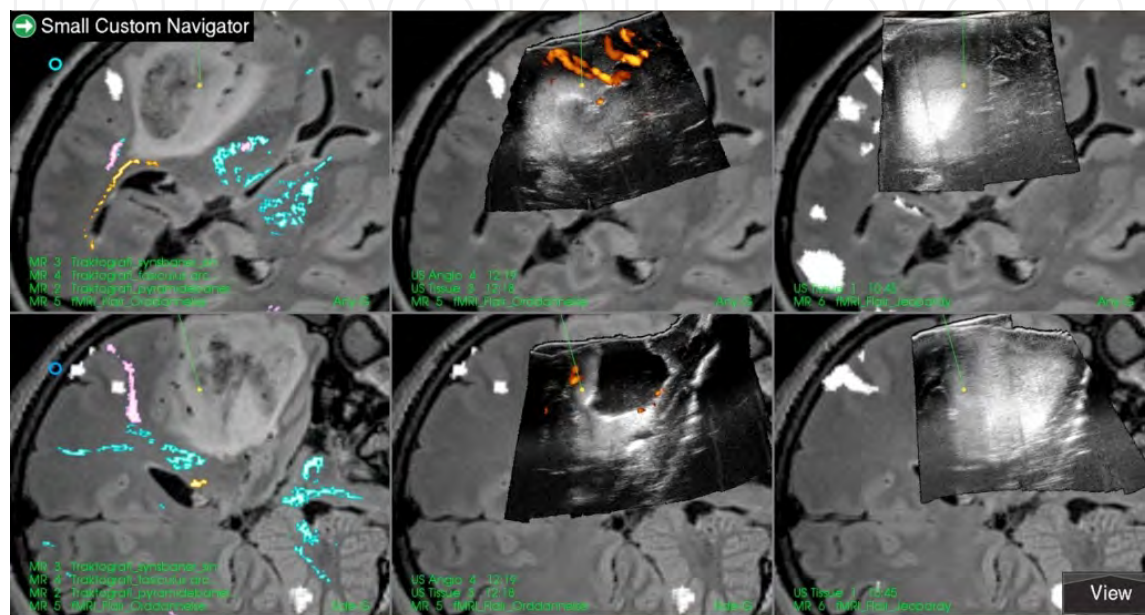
Example of multimodal visualization in navigation display. Left column shows anatomical MR image slices (FLAIR) with functional data shown as color overlay. The white spots indicate language area, the turquoise contours represent the pyramidal tract, the pink represent fasciculus arcuate (tract between language areas), the yellow represents the optic tract. Middle column shows preoperative MR image slices with intraoperative ultrasound acquired after some resection as overlay. Right column is identical as the middle, but with ultrasound data acquired prior to the start of the resection.
